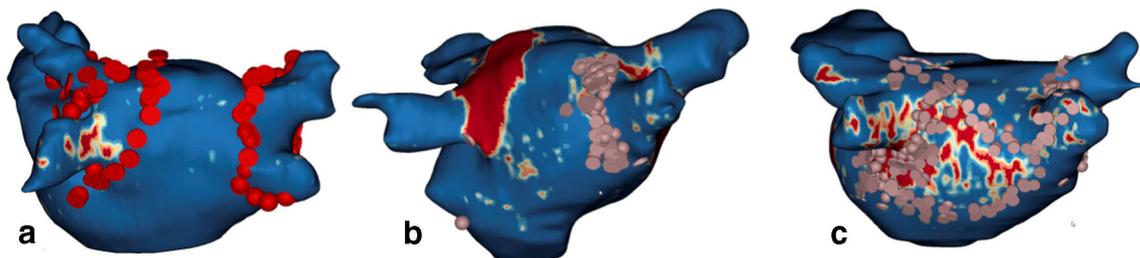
Individually tailored ablation guided by LGE-MRI. Panel a shows conventional first ablation procedure: PVI in a patient with minimal fibrosis around the veins. Panel b shows individually tailored reablation of anatomical “gaps” guided by LGE-MRI. Panel c shows
